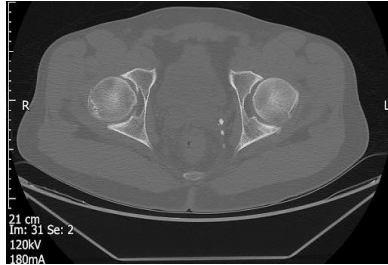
Axial CT image of the hips
